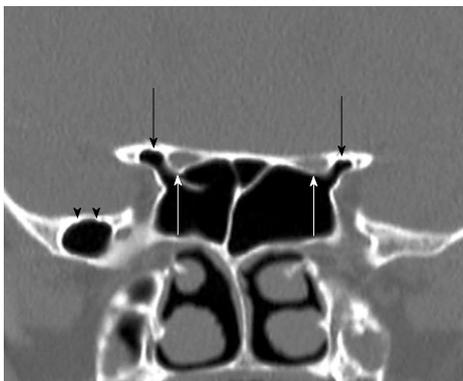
Coronal reformatted computed tomography image shows bilaterally anterior clinoid process pneumatization (black arrows) and optic nerves protrusion (white arrows) into sphenoid sinuses. Additionally shows right greater sphenoid wing pneumatization (black arrow heads).
